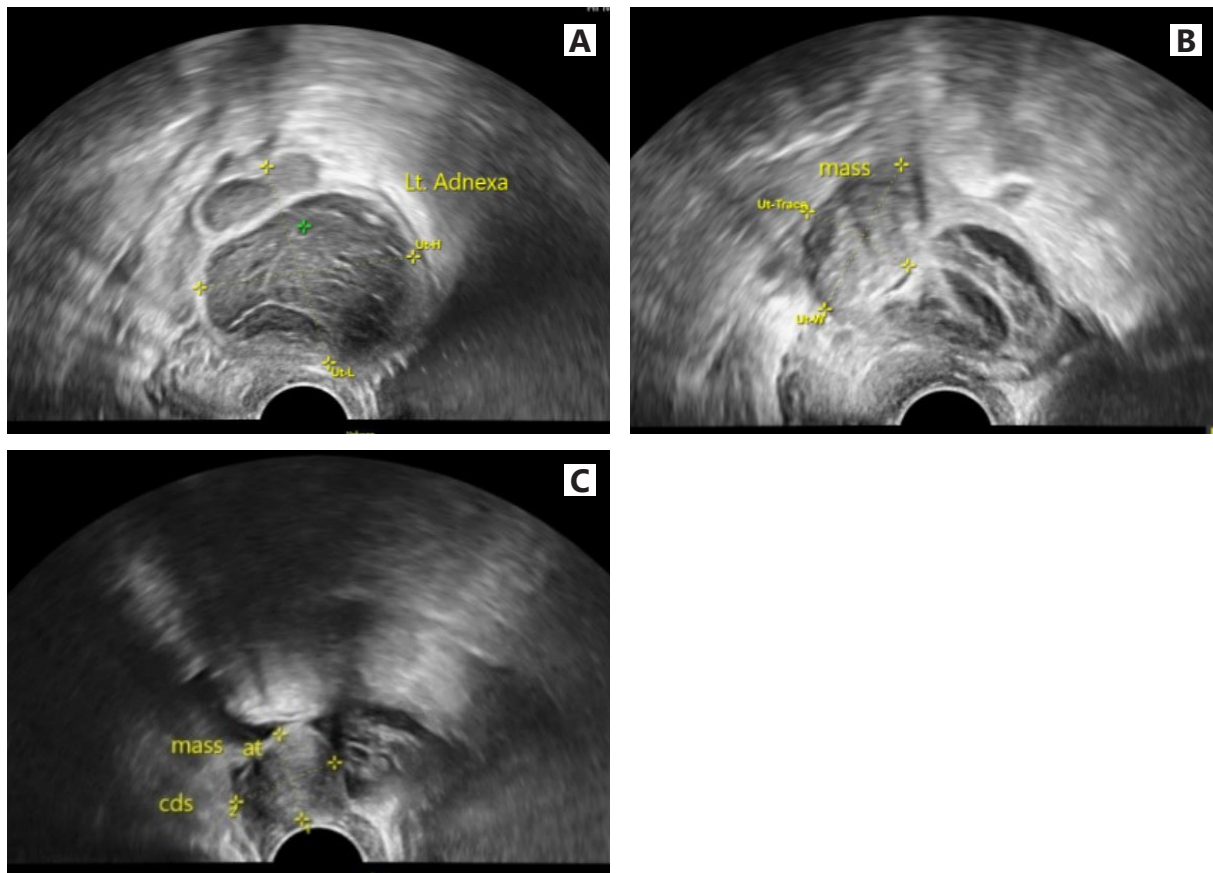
Transvaginal sonography. Sagittal ultrasound images demonstrate a multiloculated hypoechoic complex cystic mass in the left adnexa measuring 4.5 x 4.7 cm (A), with an associated solid component measuring 3.4 x 2.4 cm (B), and an additional suspicious solid mass in the cul-de-sac (C).*
